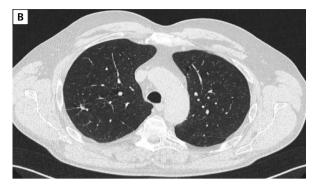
Chest computed tomography (CT) scans before (A) and after 6 months (B) of pembrolizumab treatment
